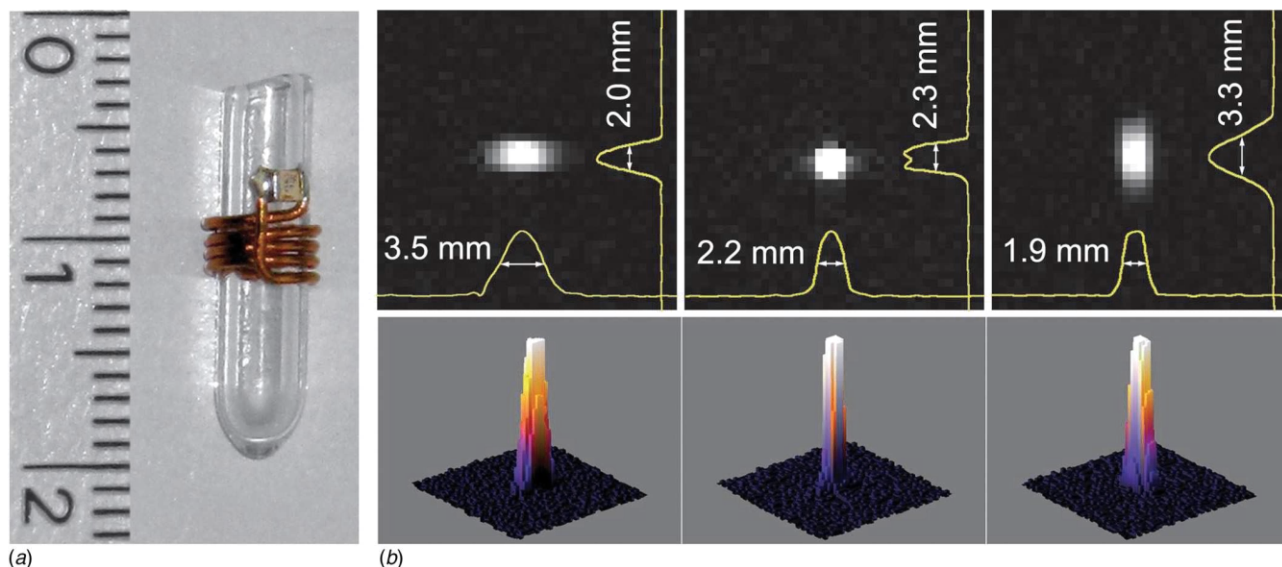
(a) Resonant RF coil as MR marker (numbers are centimeters). (b) Details ( $40 \times 40$  pixels) of marker MR images (TrueFISP sequence, flip angle of  $0.3^\circ$ , spatial resolution  $0.586$  mm/pixel) in standard views (sagittal, coronal, transverse) and respective intensity profiles. Millimeter values represent full width at half maximum of the 1D projections of the marker signals onto the respective axes.
